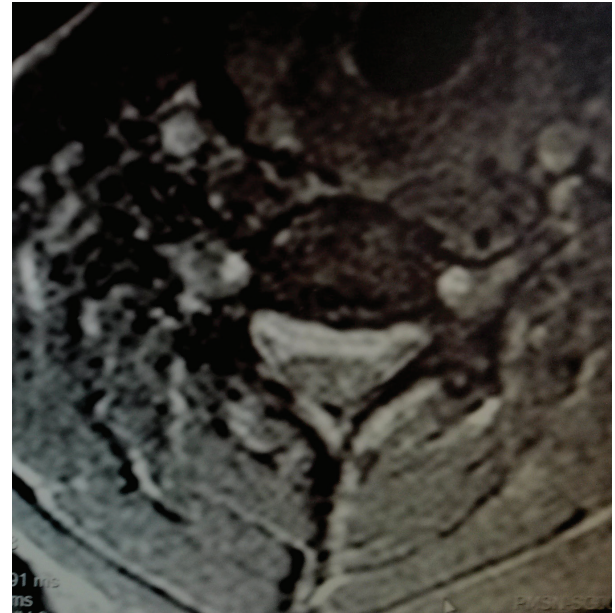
Postoperative axial T2-weighted magnetic resonance imaging
